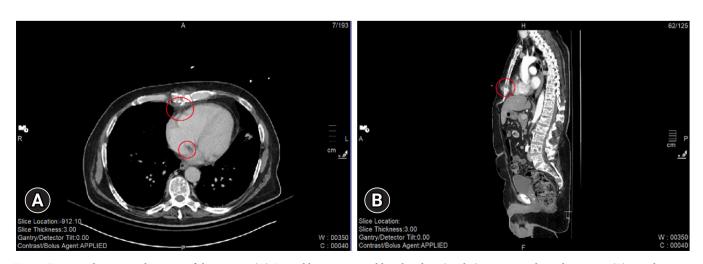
Computed tomography scans of the patient. (A) Sternal hematoma and loculated air (circles) present in the right atrium. (B) Another view demonstrating a sternal fracture (circle).
